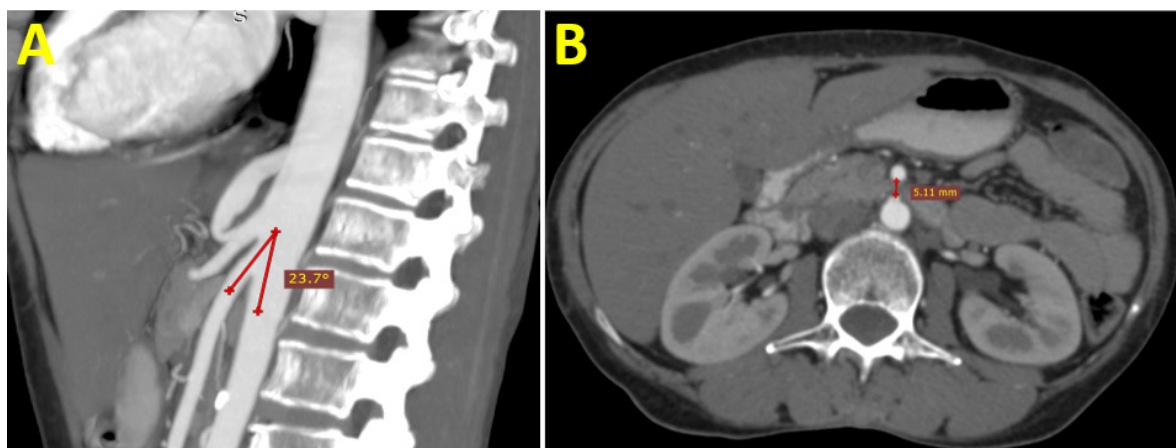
Contrast-enhanced CT scan of the upper abdomen (MIP) images. A: Sagittal reformatted image shows that the aortomesenteric angle measured 23°. B: Axial section shows the aortomesenteric distance = 5.1 mm.
